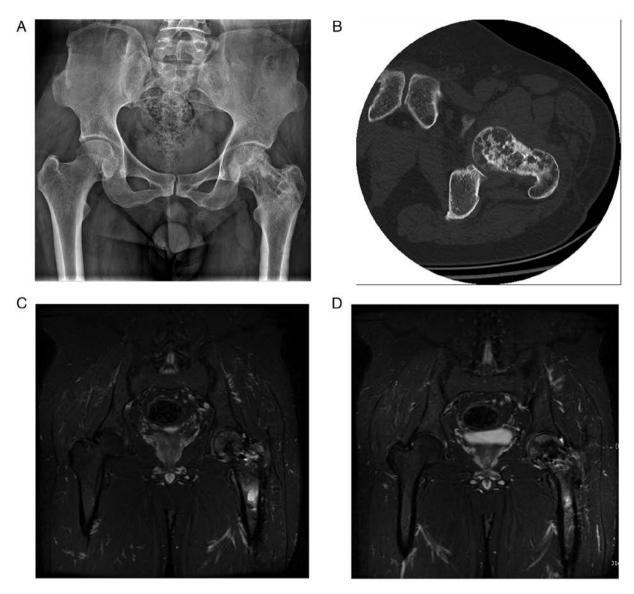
Imaging manifestations of aneurysmal bone cyst after malignant transformation: (A) X-ray examination shows heterogeneous bone density of the femoral neck. (B) CT examination reveals worm-like bone destruction of the left femoral head and neck with sclerotic bands in the tumor capsule and regular shape of the femoral head. (C) and (D) is the presence of tumour in the left femoral neck and proximal end observed on different levels of MRI. (C) MRI indicates heterogeneous bone signal in the left femoral head and neck with lengthy mixed T2 signal shadow. (D) A long T1 and long T2 signal with irregular morphology were seen in the medullary cavity of the upper femur; ~1.8 cm. Diffusion-weighted imaging exhibited a high signal.
